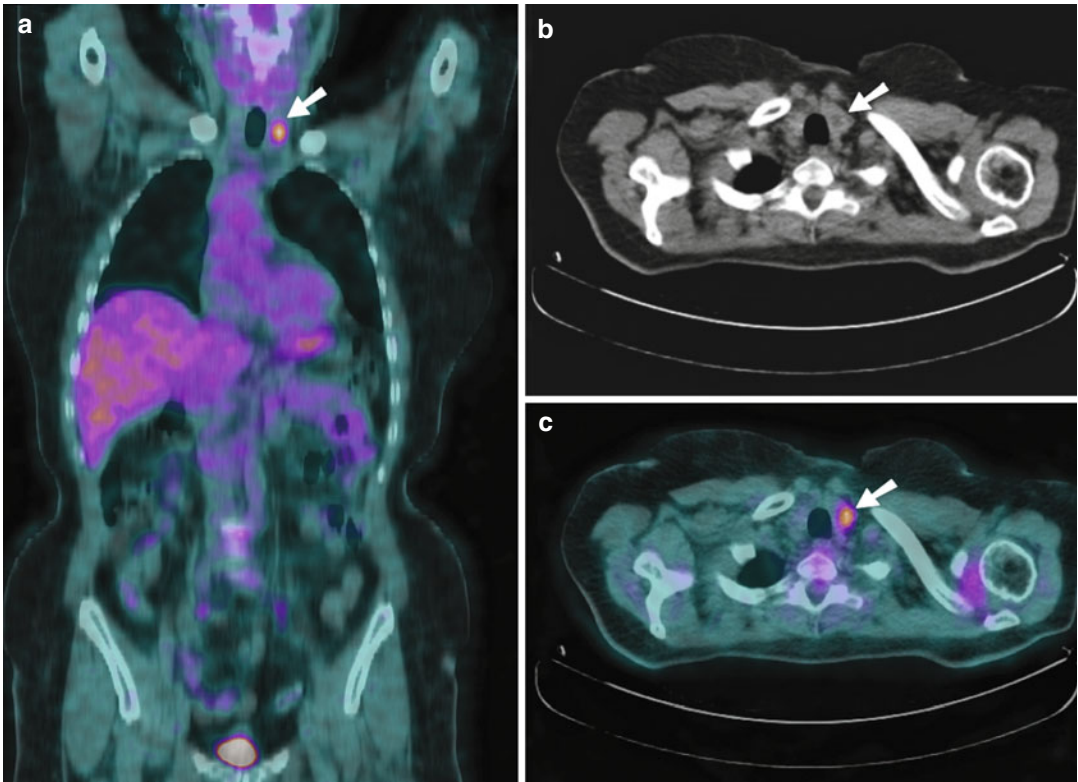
FDG PET-CT scan of a 61-year-old woman with suspected colorectal liver metastasis. (a, c) Coronal- and transaxial-fused PET-CT images showing moderate focal FDG uptake with a SUV_{max} of 4.0 (arrow) at the inferior pole of the left lobe of the thyroid corresponding to a (b)16 mm rounded lesion of mixed density on CT scan (arrow). There was no abnormal focal increased FDG accumulation seen in the liver to
